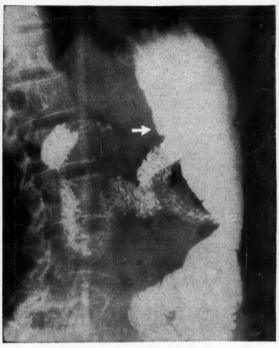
In ten weeks "the ulcer niche was no longer in evidence roentgenologically or gastroscopically."
